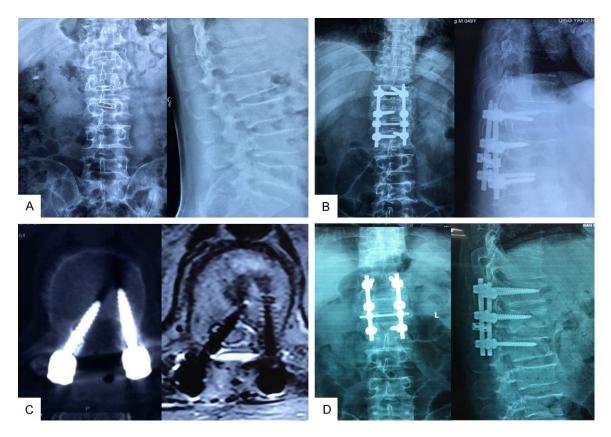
A 49-year-old male with L1 fracture underwent a posterior approach surgery in a local hospital; numbness and dyskinesia were manifested in the right lower limb after the operation. A. Preoperative X-ray showed L1 fracture; B. Posterior open reduction and internal fixation was performed in a local hospital; C. Postoperative computed to-mography (CT) and magnetic resonance imaging (MRI) showed that the right pedicle screw completely entered the spinal canal; D. 1 year after surgery, X-ray showed good fracture union.
